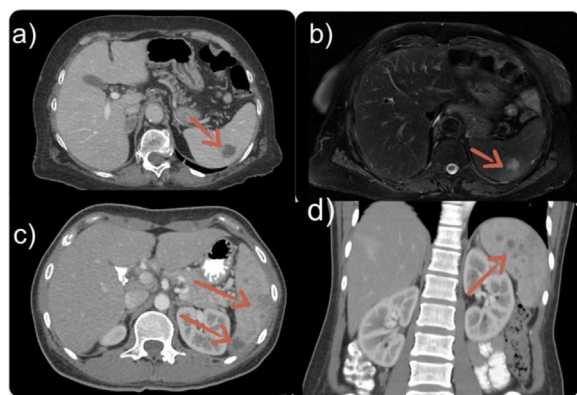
a) Case 1: Abdominal computerised tomography (CT), sagittal section. Hypodense splenic lesion; b) Case 1: Abdominal magnetic resonance imaging, T2-weighted sequence. Hyperintense splenic lesions with perilesional oedema; c) Case 2: Abdominal CT, sagittal section. Hypodense and heterogeneous splenic lesions; d) Case 2: Abdominal CT, coronal section. Hypodense and heterogeneous splenic lesions.
